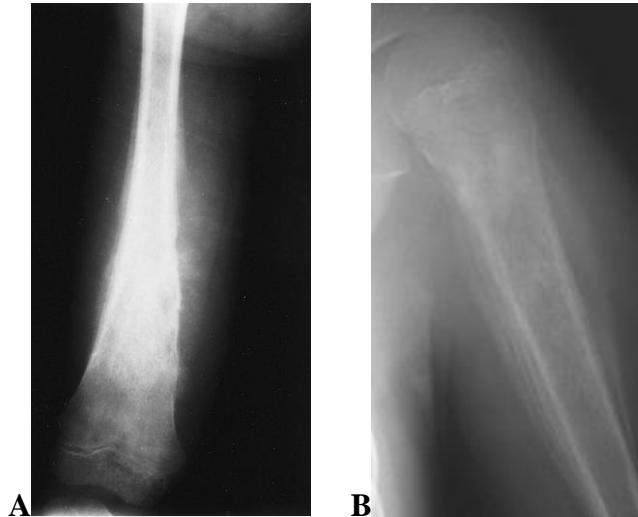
Ewing sarcoma. (A) An anteroposterior plain film of the femur of a child shows a predominantly sclerotic process with large amounts of sunburst periostitis in the diaphysis. (B) Typical appearance in the proximal humeral metadiaphysis with permeative marrow destruction, ‘hair-on-end’ and multilaminated periosteal reaction
